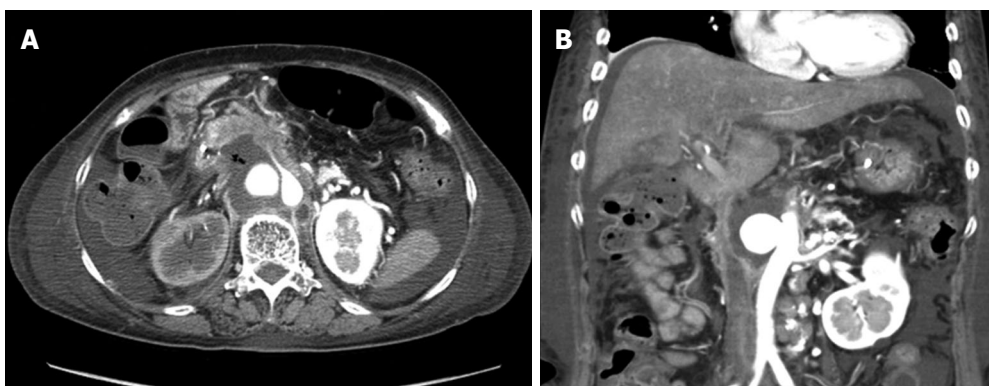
Abdominal CT scan showing decreased air densities in the pancreatic head to the paraaortic area (A) and a circular contrast collecting aneurysm of aorta (B).
